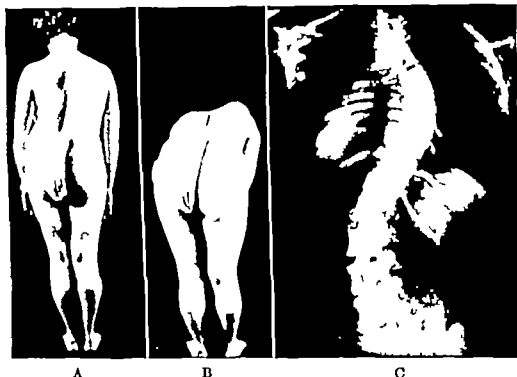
Moderate right dorsal scoliosis. A. Patient in upright position. B. Patient in forward bent position. C. Roentgenogram of spine.
